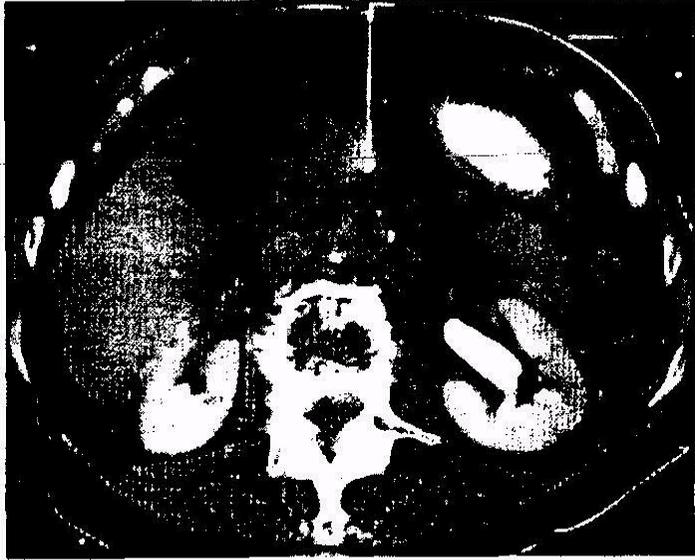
Unresectable pancreatic carcinoma. CT guided fine-needle aspiration biopsy confirming the diagnosis of pancreatic carcinoma (*Rose et al., 2009*).
